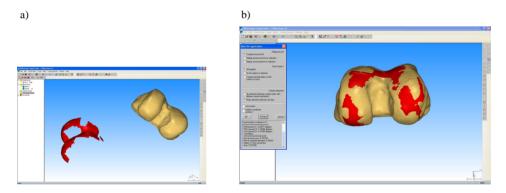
Accuracy analysis of the of surface mapping of the knee condyles: a) reference surface model (left), model from CT test (right side); b) the results of the imposition of the model and artifact.
